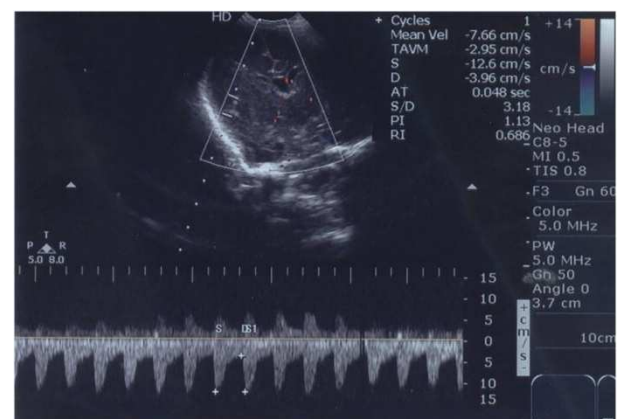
Ultrasound coronal scan through temporal window enabling visualization of the right middle cerebral artery show normal wave flow pattern with high resistive index
